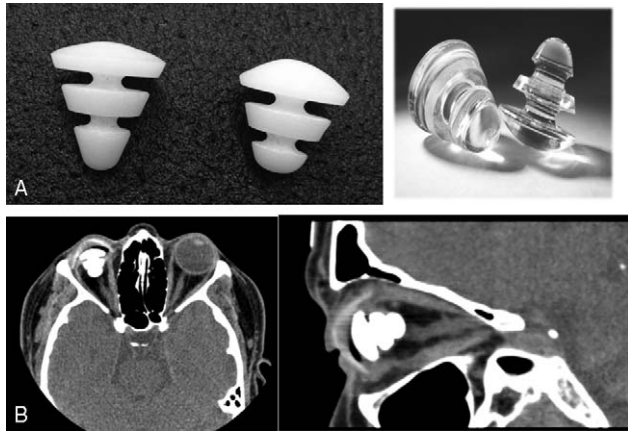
(A) Biosilicate tapered implants (left) and PMMA implants (right). Both implants are represented in the 2 sizes used in the study (18 mm and 16 mm). (B) CT scan of a patient with a 16-mm Biosilicate implant showing good implant positioning, without rotation, and the final maintenance of the orbital volume after 180 days of follow-up. CT, computed tomography; PMMA, polymethylmethacrylate.
